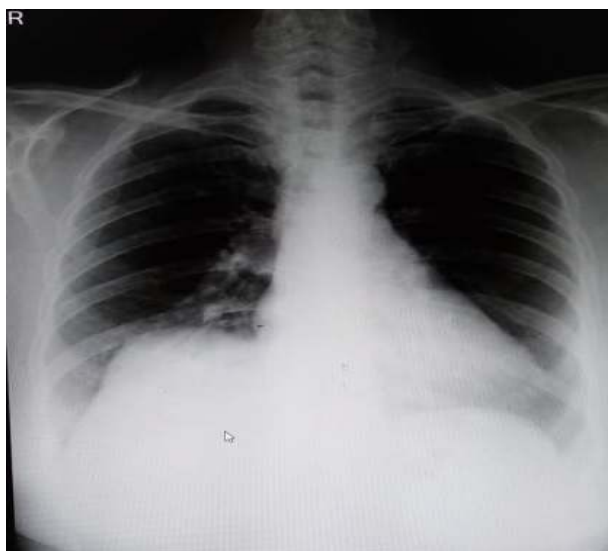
chest x-ray showing complete resolution of left effusion after 2 months
